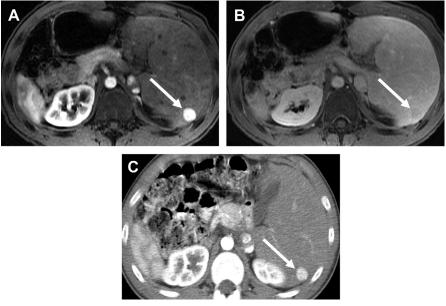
An 18-year-old boy with history of Fontan procedure and situs inversus. Axial MR imaging shows avidly enhancing lesion (*arrow*) on hepatic arterial phase (*A*) with subsequent washout and enhancing capsule on venous phase (*B*). Contrast-enhanced CT obtained 5 years later (*C*) shows stable size of the lesion suggestive of benignity (despite the worrisome enhancement pattern).
